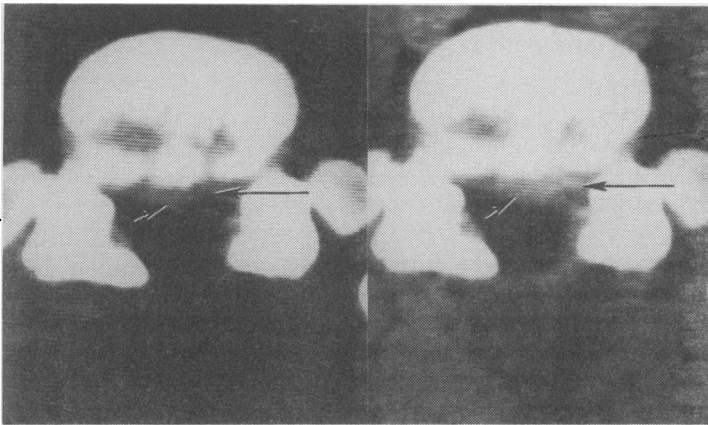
(a) and (b). Mixed recurrent disc protrusion and epidural fibrosis. CT scans before (a) and after (b) intravenous contrast. Non-enhancing disc material indents thecal sac (short arrow); enhancing fibrosis is seen laterally around nerve root (long arrow).
